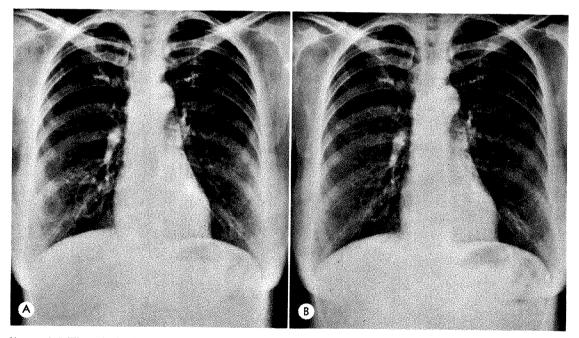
(A) The solarized copy is almost a perfect reproduction of (B) the original roentgenogram. Inspection of the chest roentgenograms is necessary to identify the copy and the original.
